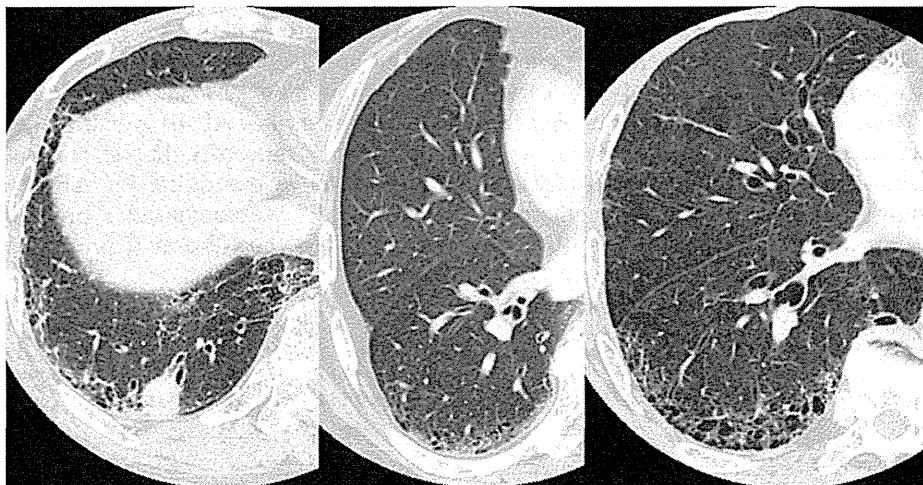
Preoperative high-resolution computed tomography in 3 patients with computed tomography honeycombing. Diffuse subpleural dorsal honeycombing with focal fibrotic changes can be seen.
